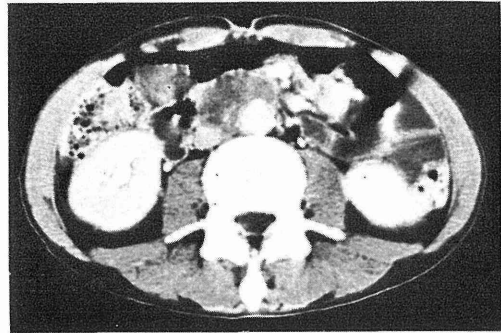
Abdominal CT after chemotherapy.
